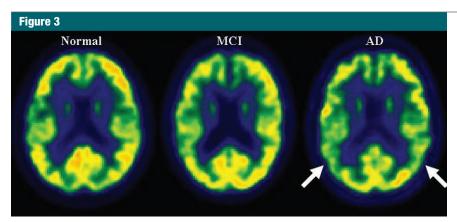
Typical FDG PET uptake pattern in AD. Decreased FDG uptake in lateral temporoparietal cortex (arrows) and posterior cingulate—precuneus area is seen in the AD subject and more mildly in the MCl subject.
